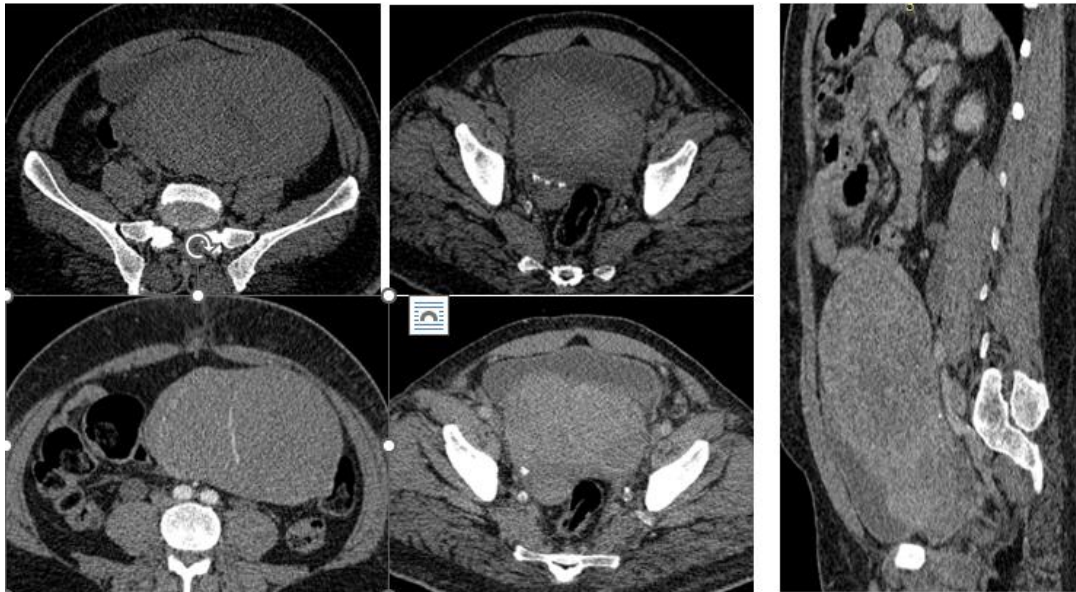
Abdomino pelvic CT scan showing a voluminous bdominopelvic tissular mass, with lobulated contours and well-defined boundaries. The mass contains calcifications and areas of fatty density, and shows heterogeneous enhancement upon contrast administration. The mass displaces the bladder downward and infiltrate the seminal vesicles and the prostate. Anteriorly, it came into intimate contact with the abdominal wall.
